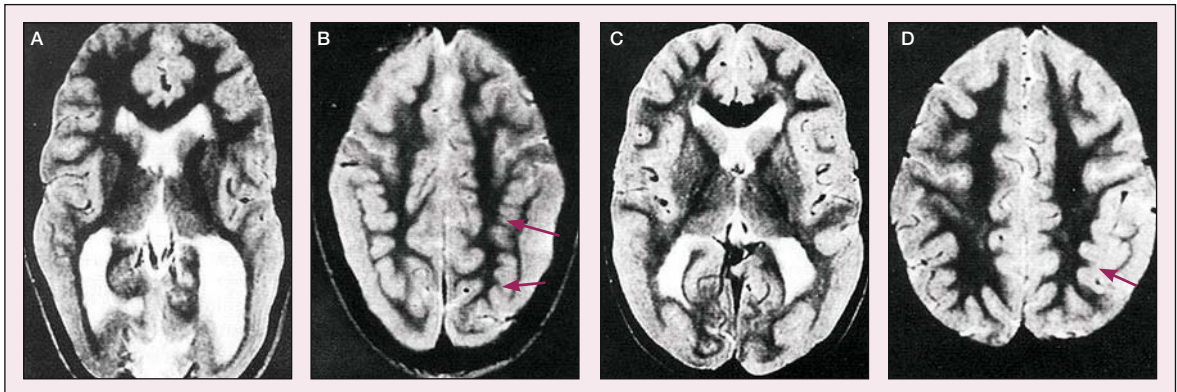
Axial T2-weighted MRI scans from the older (A,B) and younger (C,D) brothers. There is marked posterior agyria–pachygyria with areas of polymicrogyria mainly in the parietal cortex. Reproduced with permission from Ferrie, et al (1995).⁴⁹
